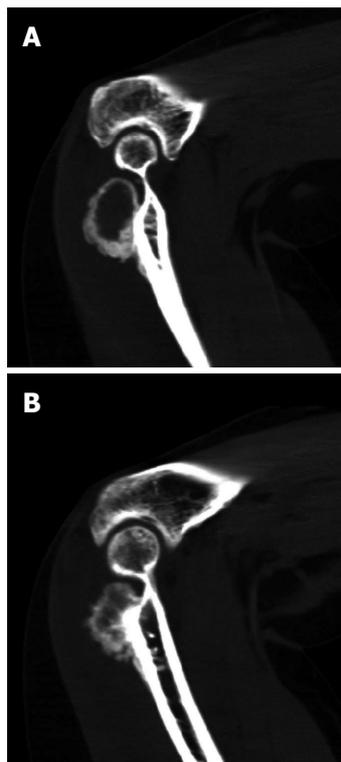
Computed tomography scan 11 wk after the initial imaging showing a 2.0 cm x 1.9 cm osseous excrescence arising from the posterior distal humeral metaphysis.
